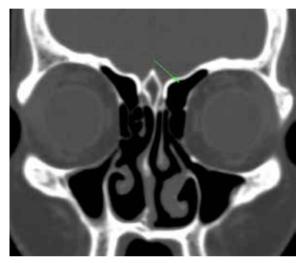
CT scan PNS coronal section showing agger nasi cell on the left.
